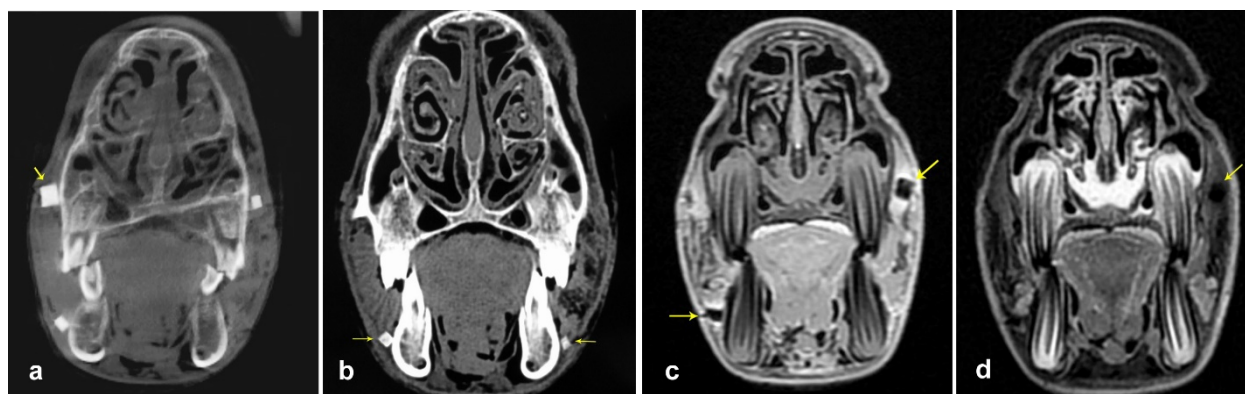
The CBCT (a), CT (b), MRI-T1 (c) and MRI-T2 (d) images showing rubber foreign bodies (arrows)
